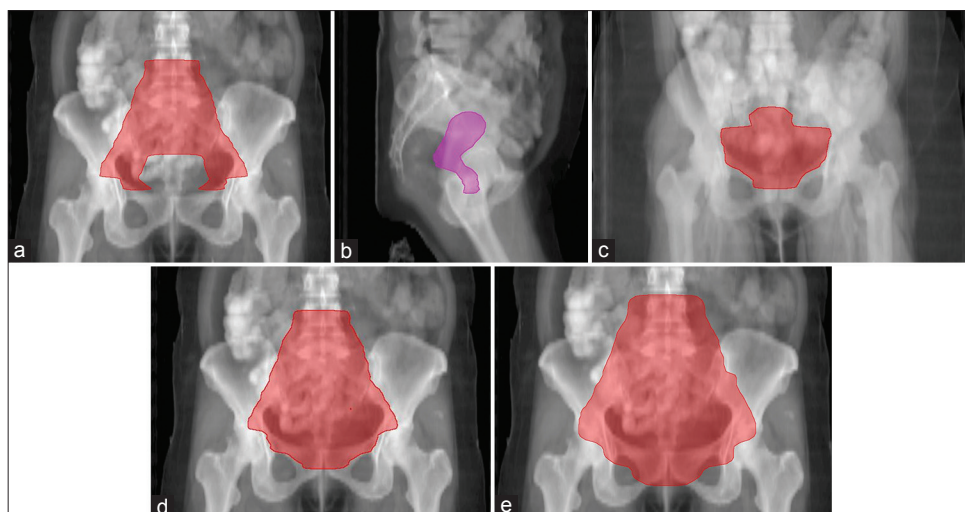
Digitally reconstructed radiographs showing CTV for: CTV 1 (a), CTV 2 (b), CTV 3 (c), CTV total (d), PTV final (e)
